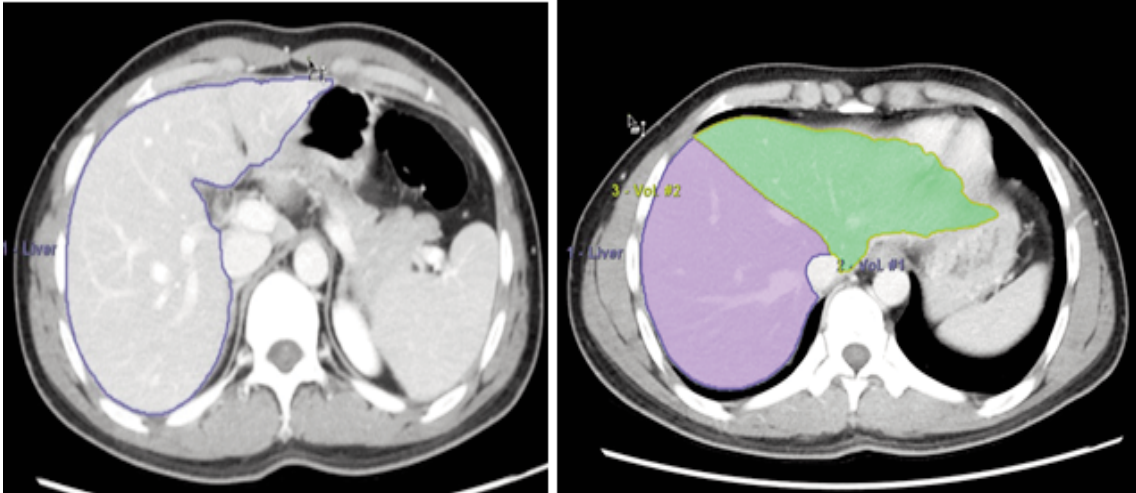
Hepatic contour tracing with manual correction and liver segmentation with virtual cut during computed tomography (CT) volumetry.
